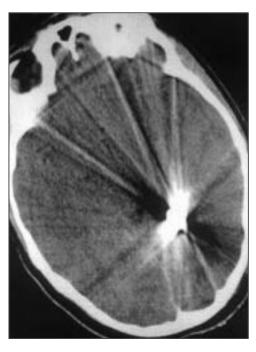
CT scan showing a bullet in the deep left occipital lobe.
